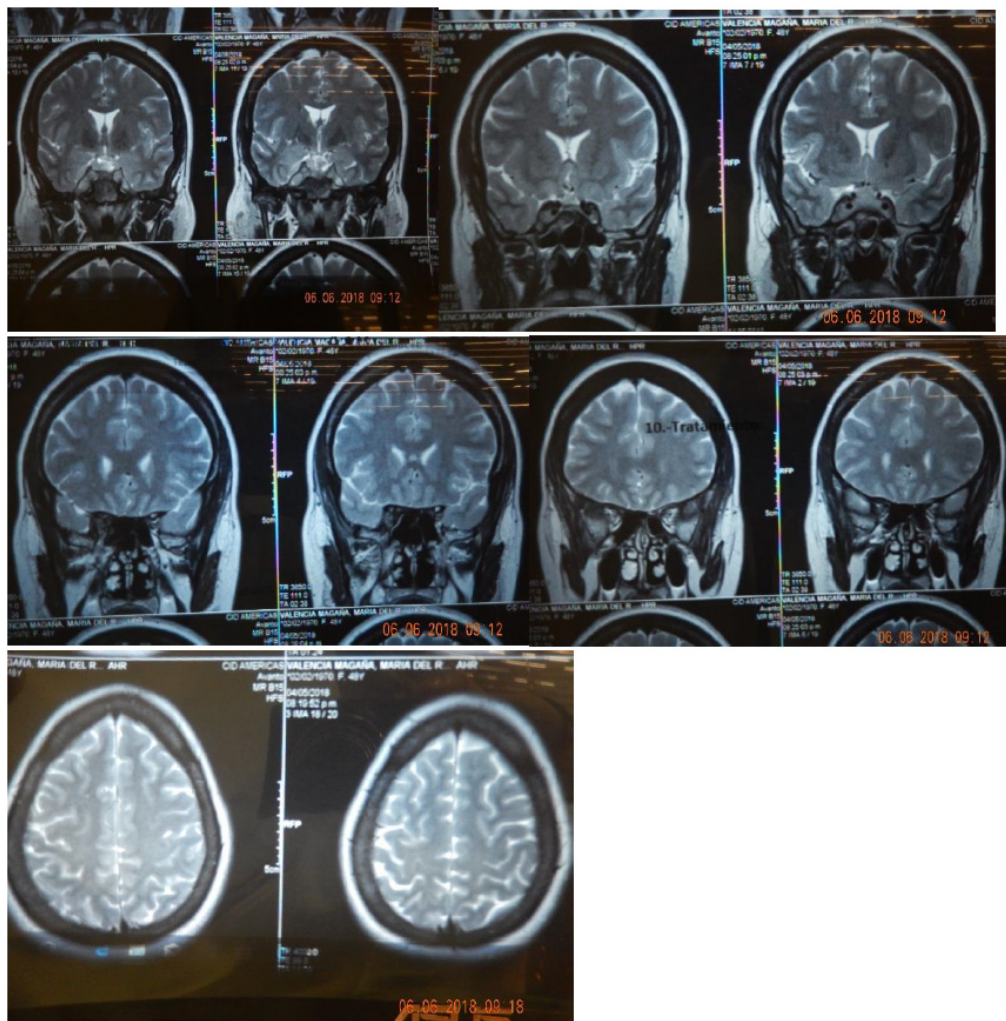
These retrieved images were taken from the MRI study with data 04/05/2018.
